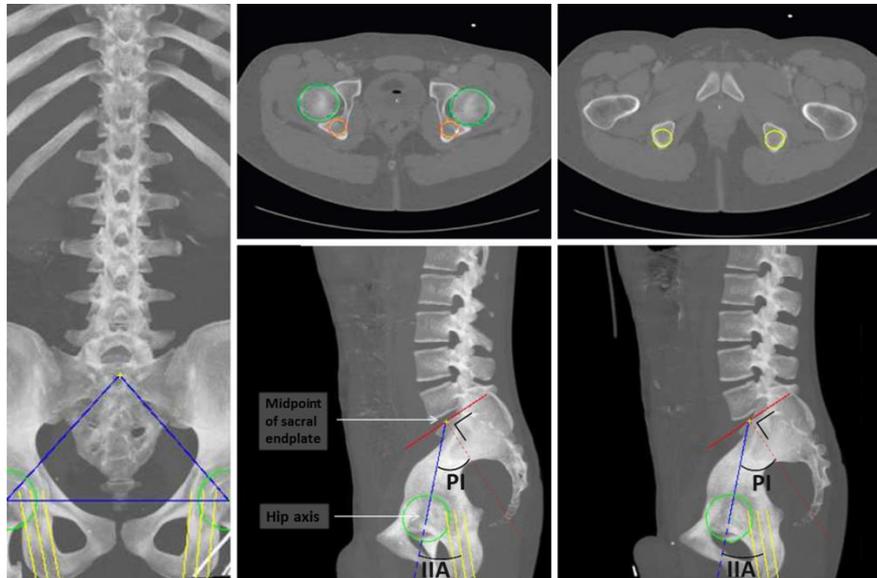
Computerized measurements of the ischio-iliac angle (IIA) and PI on CT scans, using in-house development software. Image courtesy of (Schlösser, et al., 2014)
